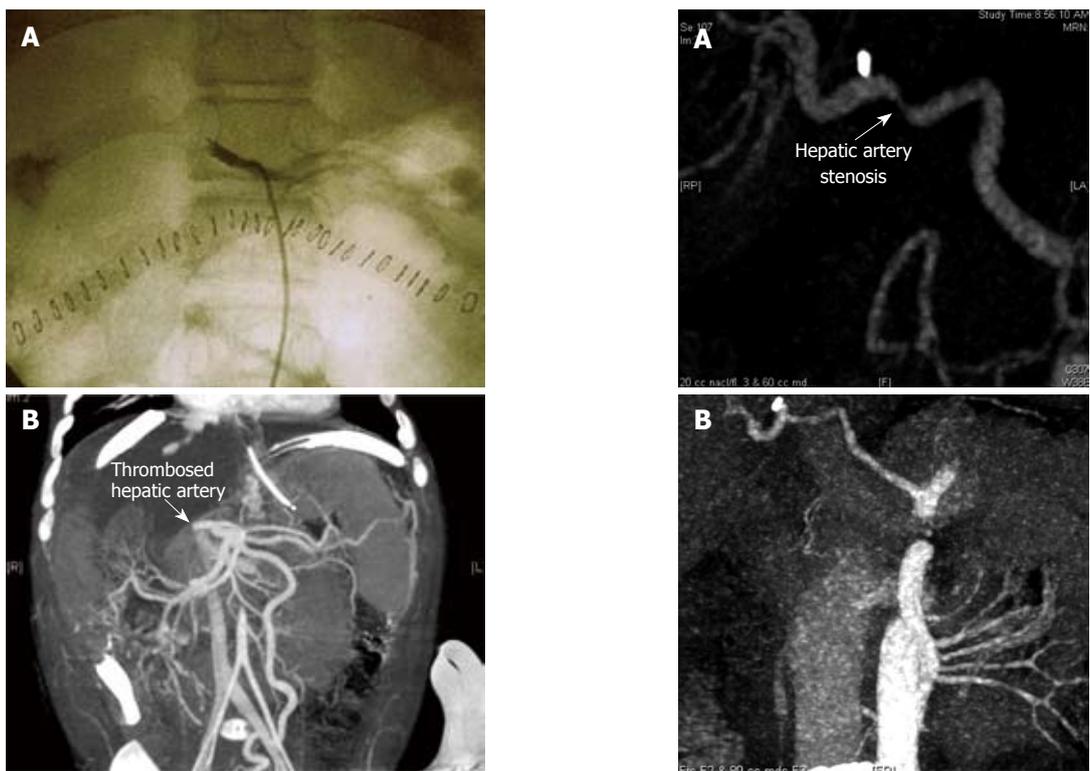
Selective celiac angiography showing early hepatic artery thrombosis after left lateral segment transplantation. A: Conventional angiography is the gold standard for radiographic diagnosis of hepatic artery thrombosis. B: Nowadays, the sensitivity of multiphase, multislice computed tomographic angiography with multidetector reconstruction approaches that of conventional angiography.
